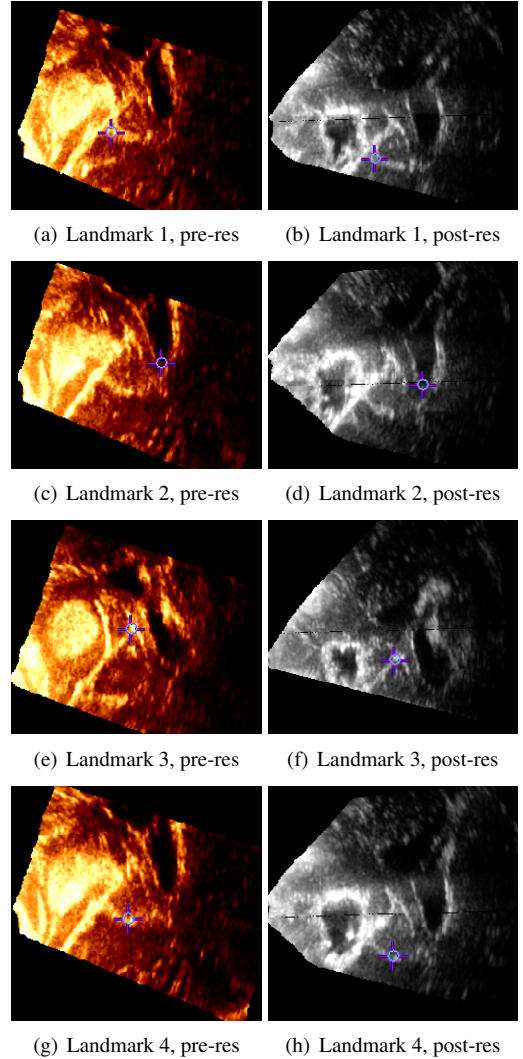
Four corresponding homologous landmarks shown in the pre- and post-resection ultrasound slices of patient P8. There are 10 corresponding landmarks in this patient's data.
